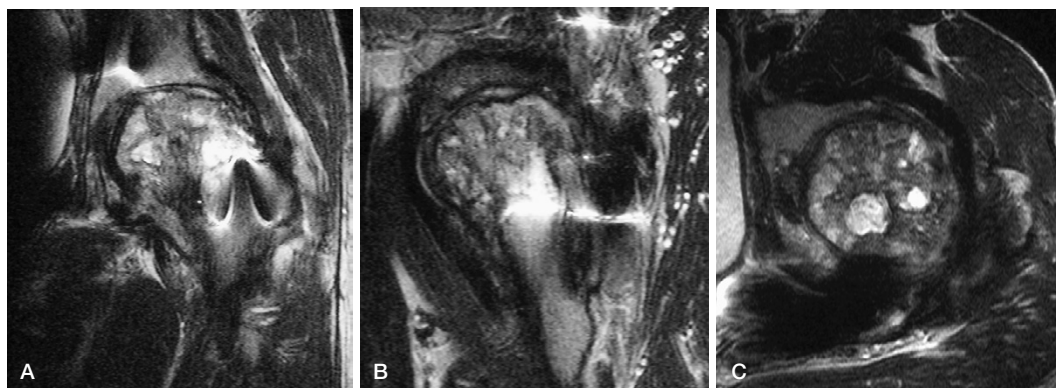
MRI at 12 months post-ACI demonstrates a variable thickness of cartilage overlying an irregular subchondral bone outline. The subchondral cysts and areas of sclerosis with loss of normal marrow signal are clearly visible. A. coronal view, T2-weighted TSE (TR 4000, TE 96, echo 7); B. sagittal view, T1-weighted SE (TR 570, TE 20); and C. axial view, T2-weighted TSE (TR 4000, TE 96, echo 7).
